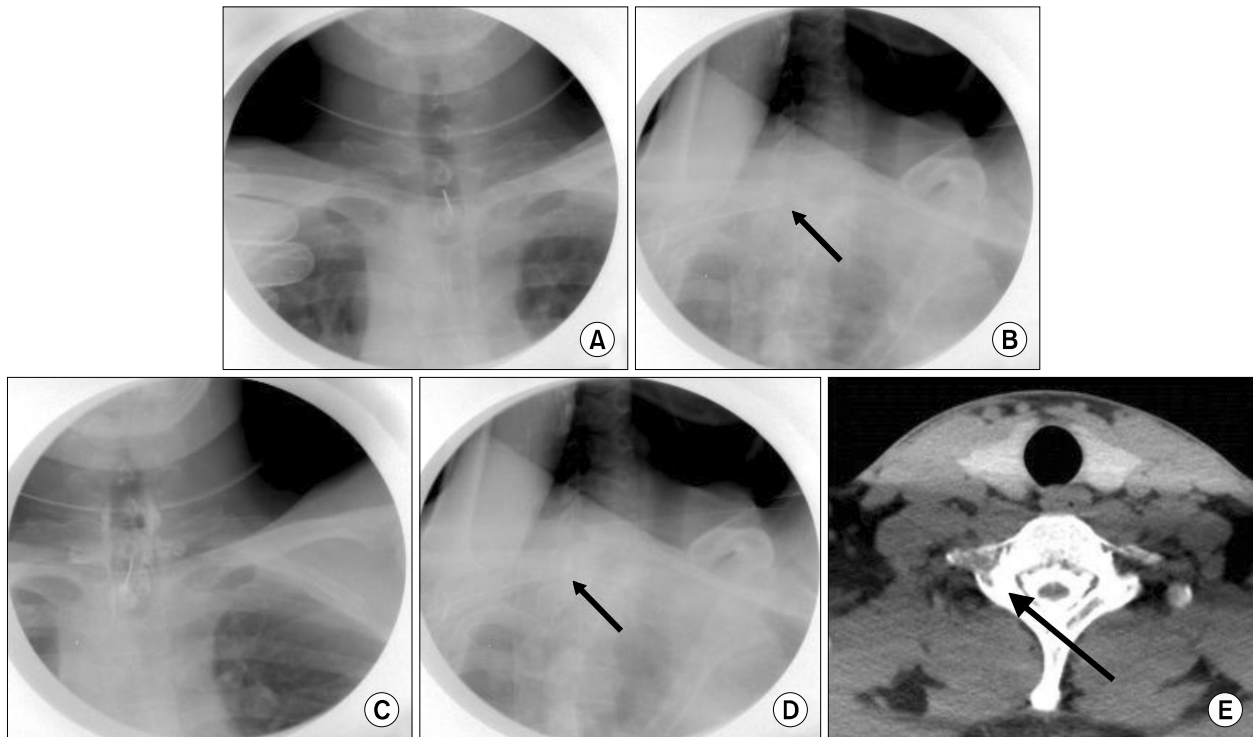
AP and the alternative oblique views under fluoroscopy. AP view (A) and the alternative oblique view (B) under fluoroscopy; the contralateral laminae are seen in complete cross-section view. Epidural space was confirmed with contrast dye injection (C and D). Angle of the X-ray beam was parallel to the C7 lamina plane (E). Arrow indicated a hollow tube.
